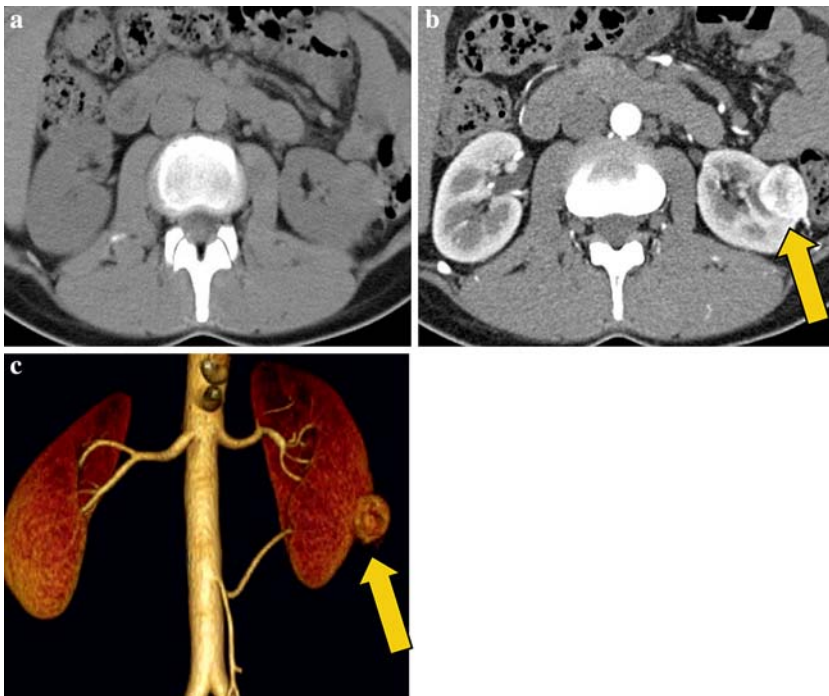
CTA of hypervascular renal cell carcinoma. Unenhanced CT (A), arterial phase contrast enhanced CTA (B), and VR CTA (C) of the abdominal aorta and renal arteries reveal a hypervascular mass (*arrows*) in the lower pole of the left kidney consistent with surgically proven renal cell carcinoma.
